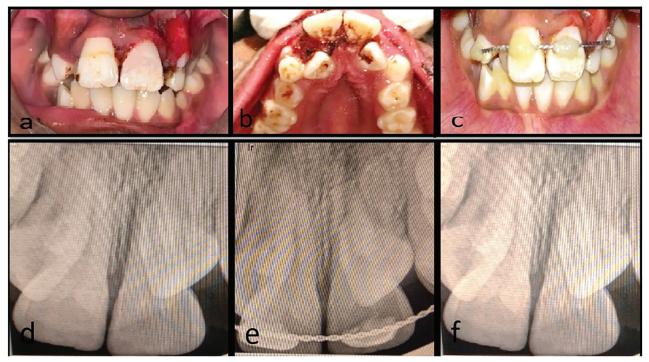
a. Pre-operative frontal view showing reimplanted #21; b. Pre-operative maxillary occlusal view showing traumatic injury to maxillary incisors; c. Post-operative frontal view showing flexible splint; d. Pre-operative radiograph; e. Post-operative radiograph; f. Radiograph after 3 months follow-up
